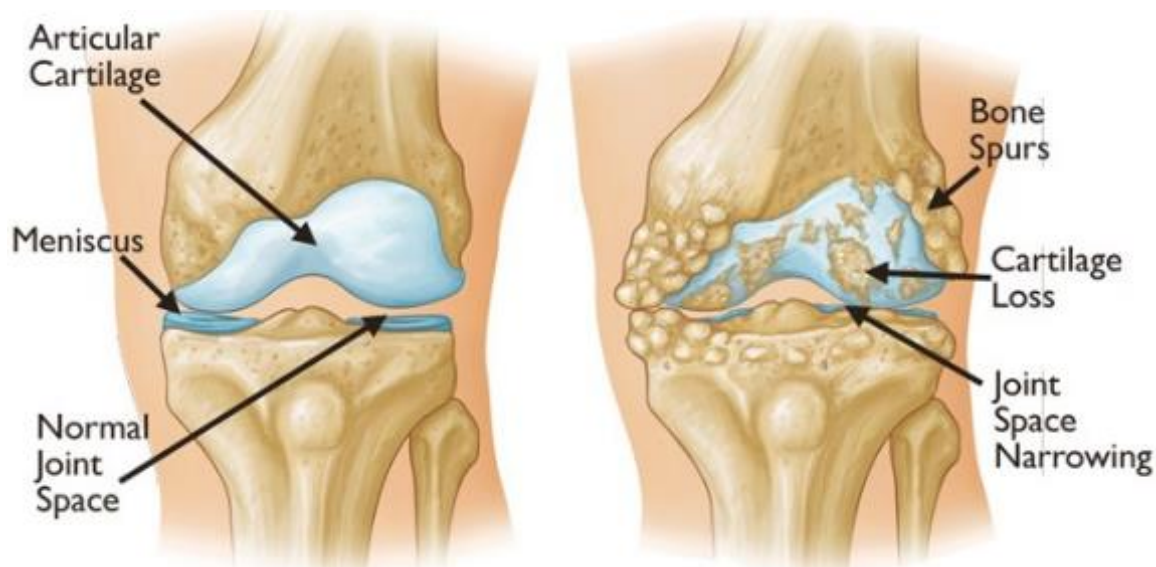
Comparison of healthy and osteoarthritic joint. Note structural changes, most specifically the narrowing of the joint space, which is commonly used to diagnose OA radiographically (adapted from AAOS.org).
